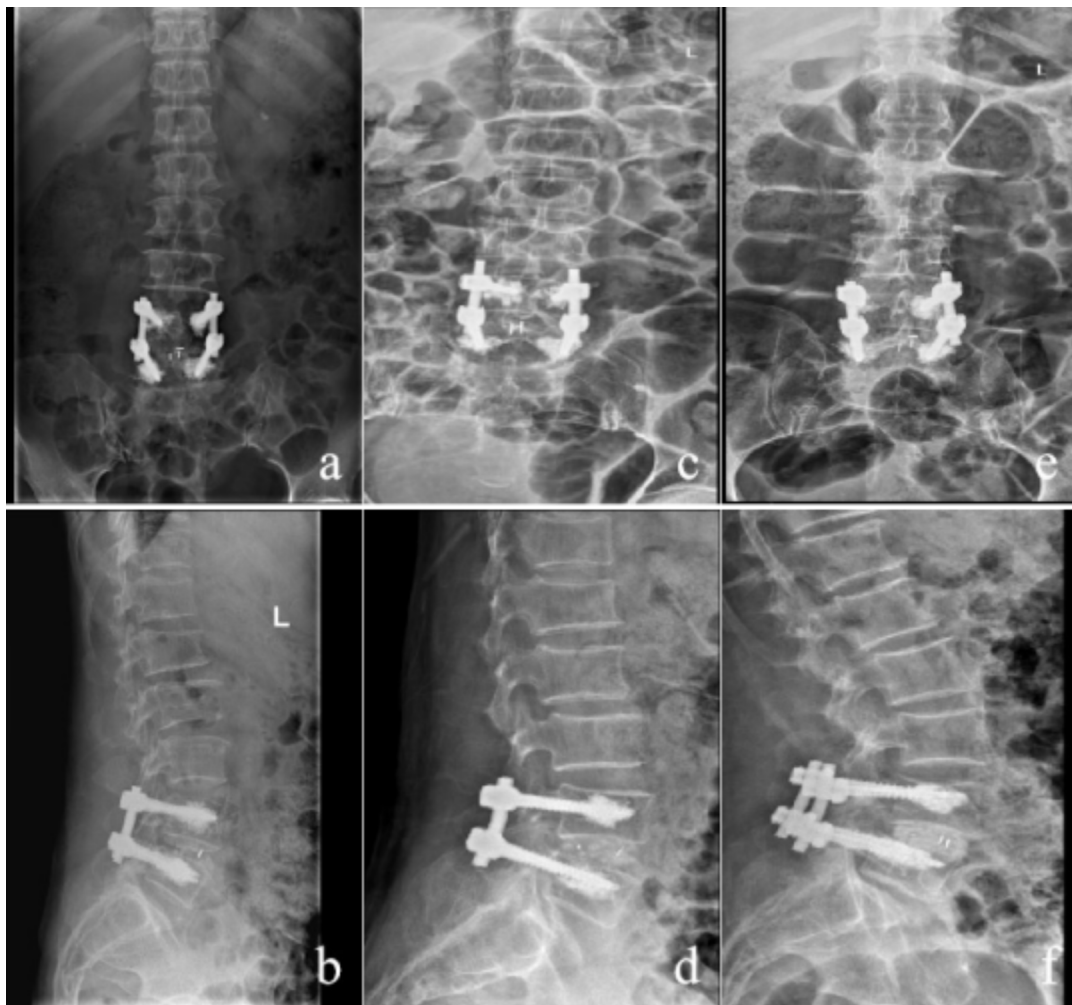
a-b, Frontal and lateral radiographs of the lumbar spine at 3 months postoperatively showed a well-positioned pedicle screw with no retraction of the nail. No collapse of the intervertebral fusion was observed. c-d, 6 months postoperatively, frontal and lateral radiographs of the lumbar spine showed well positioned pedicle screws with no retraction of the screws. The intervertebral fusion did not collapse, and intervertebral trabeculae formation was visible. e-f, At the last follow-up, the frontal and lateral lumbar spine radiographs showed an increase in intervertebral space bone trabeculae compared to 6 months postoperatively and intervertebral bony fusion, which was classified as grade I according to Bridwell's fusion criteria.
